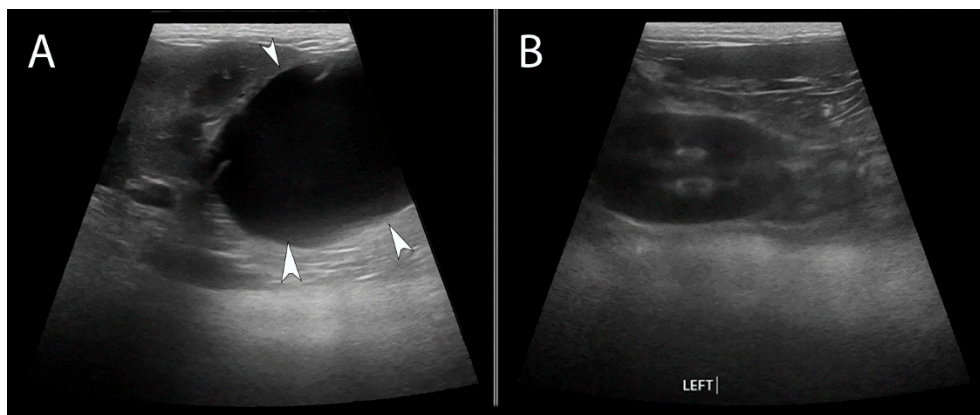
Ultrasound examination of the kidneys. A - Significant anechoic fluid-filled distension of the renal pelvis and compression of the renal parenchyma (white arrowheads) B – Left kidney with no remarkable changes
